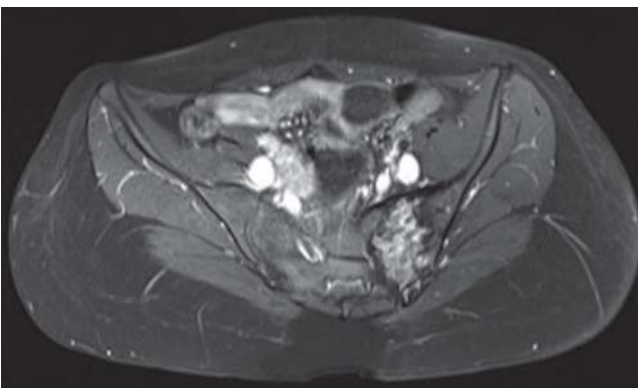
Axial MRI scan (T1 TSE FS with contrast medium) 32 months after embolisation. Minimal further reduction of tumor size ($2.8 \times 4.8 \times 4.9$ cm) and ongoing transformation of cystic areas into fibrous components.
